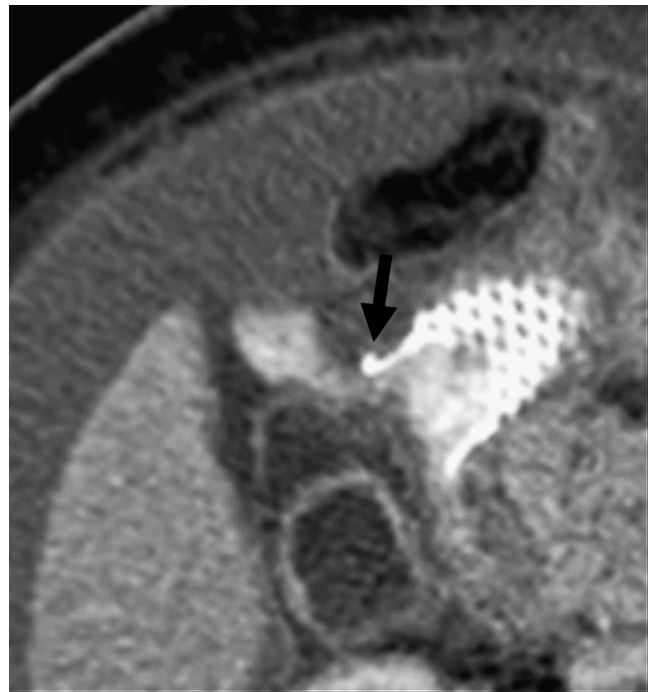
Multiplanar reconstruction from the CT data set in the oblique plane at the distal landing site of the stent confirmed perforation of the wall of the duodenum by the stent strut (arrow), with direct extravasation of oral contrast from the bowel lumen into the peritoneal cavity.
